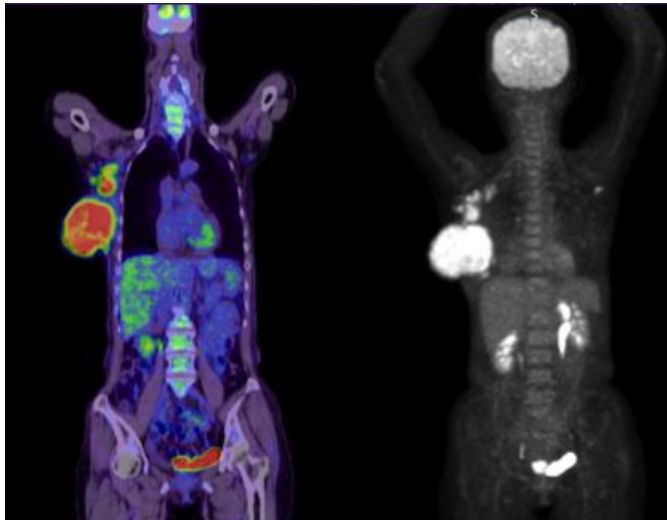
CECT scan showed a huge right breast tumour with multiple enlarged axillary LN . PET CT Scan showed increased FDG uptake of right breast lump and axillary LN
